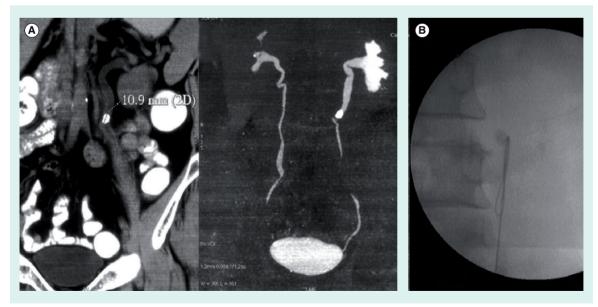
Impaced calculi and its management. (A) Computed tomography urography showing a 10.9-mm stone in left upper ureter with proximal hydroureteronephrosis. (B) Inability to pass safety glidewire across the stone into the proximal portion may necessitate certain additional maneuvers.
